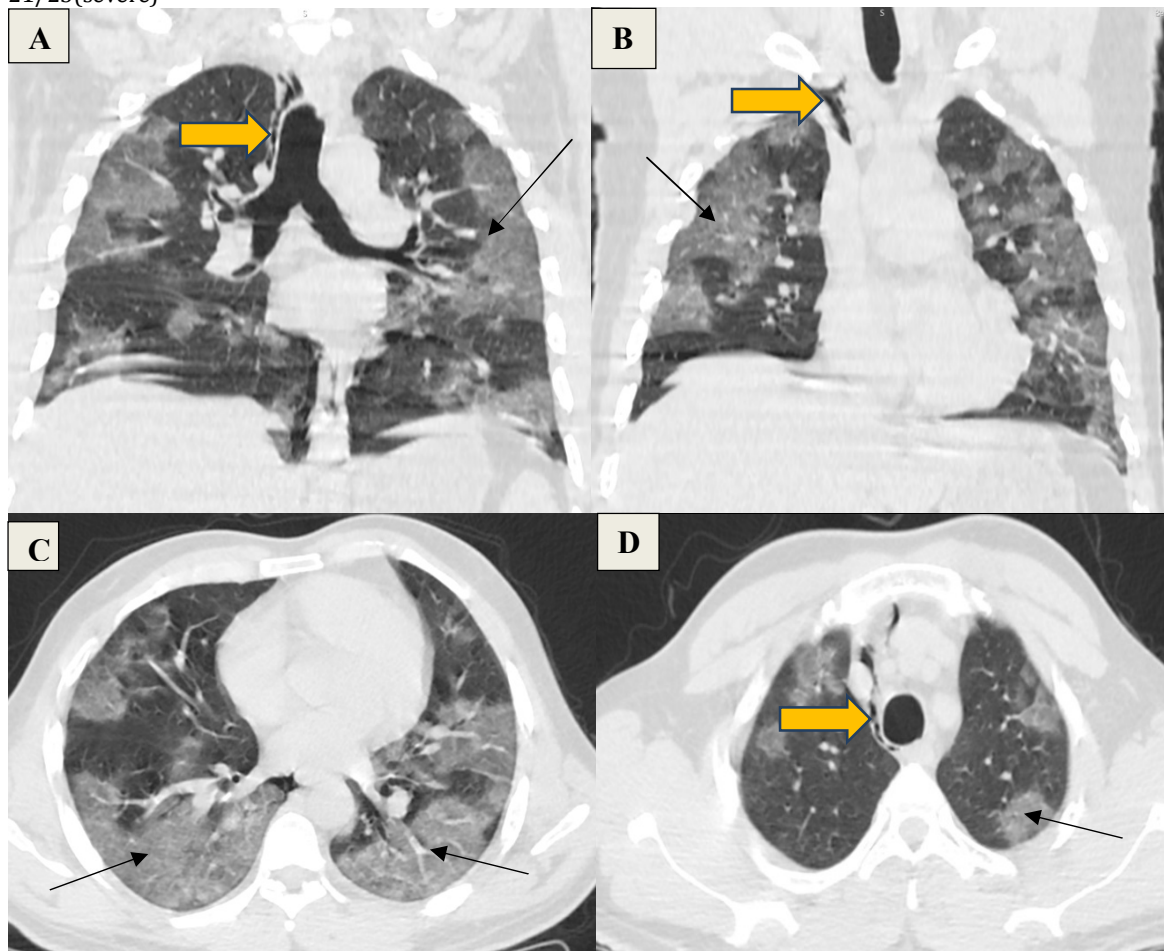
A,B,C&D) a 37 year old male smoker, coronal and axial sections of CT chest showing and right upper pneumomediastinum(orange arrow) with patchy ground glass opacities(black arrow) in bilateral lung fields categorized as CORADS-6, CT Severity score – 17/25(severe)
